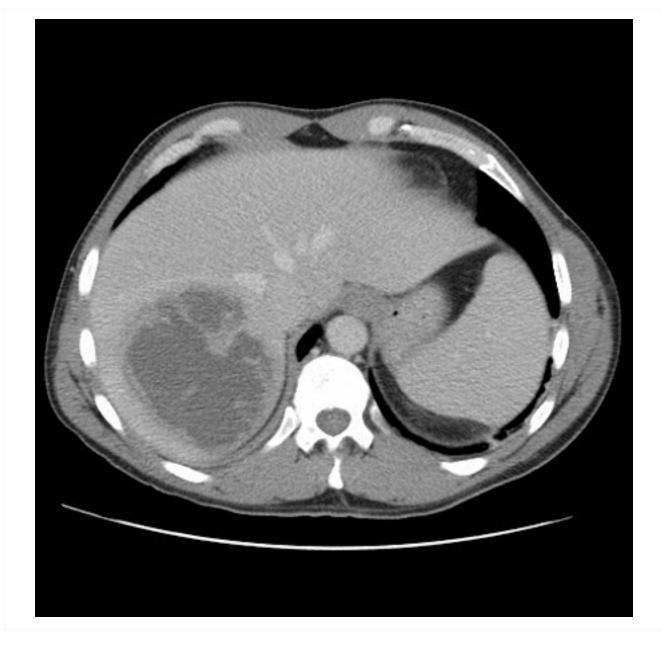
Liver abscess: CT scan (coronal view) showing liver abscess in a 46-year-old man who presented with fever, fatigue, and cough
